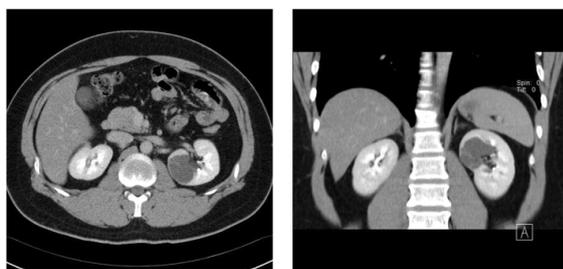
Computed tomography with contrast enhanced.
